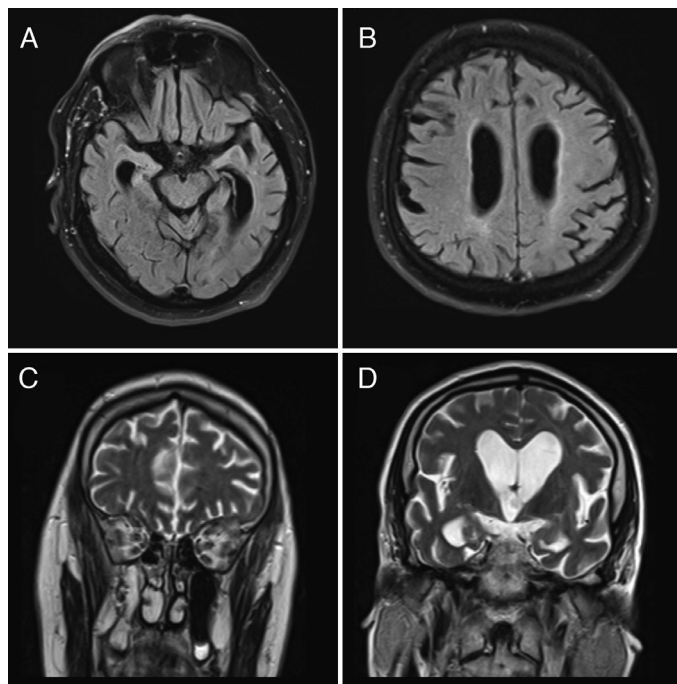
(A) Asymmetrical atrophy in the hippocampal and parahippocampal regions, which is more prominent on the left in the fluid-attenuated inversion recovery axial images of the cranial magnetic resonance imaging of the patient. (B) Enlargement of the sulci consistent with atrophy in the left parietal region. (C, D) While bilateral symmetrical atrophy can be seen in the frontal region in T2 coronal images, prominent bilateral asymmetric atrophy can be seen in the temporoparietal regions on the left
